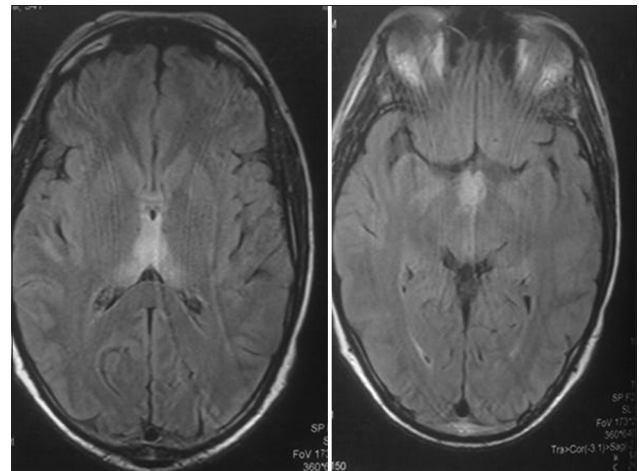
There is evidence of FLAIR hyperintensity involving medial thalami, mammillary bodies, and around third ventricle, suggestive of Wernicke's encephalopathy
